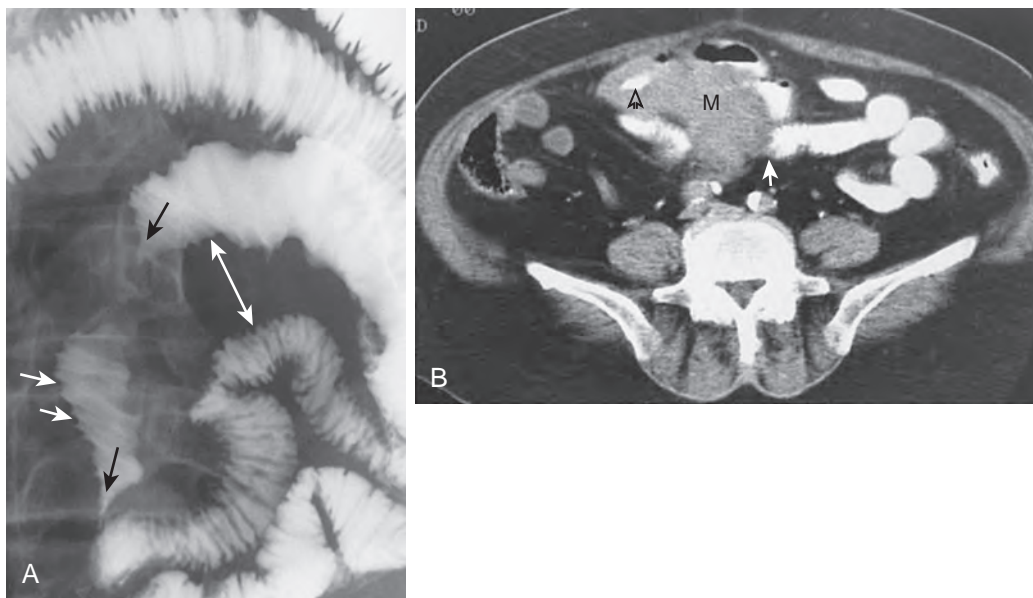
Non-Hodgkin's lymphoma secondarily arising in the small bowel mesenteric lymph nodes, partially obstructing the small intestine. A. Overhead image from enteroclysis shows that pelvic ileal loops are separated (double arrow) by a presumptive mass in the small bowel mesentery. The small bowel is narrowed, tapered, and partially obstructed at several sites (black arrows). Thick small bowel folds (white arrows) could be the result of ischemia caused by venous or lymphatic obstruction in the mesentery or direct tumor invasion. B. CT clarifies the radiographic findings. Separation of bowel loops is caused by a large, homogeneous mesenteric mass (M). A loop of intestine is tapered and partially obstructed (arrow). The tumor circumferentially infiltrates one intestinal loop (open arrow), accounting for the thick folds seen on the enteroclysis. (A from Rubesin SE, Gilchrist AM, Bronner M, et al: Non-Hodgkin lymphoma of the small intestine. *RadioGraphics* 10:985-998, 1990.)
